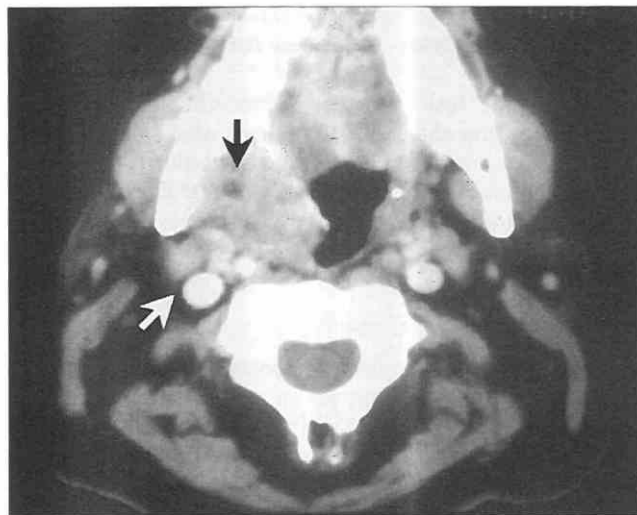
Prestyloid compartment parapharyngeal space infection from spread of tonsillitis. Axial contrast-enhanced CT scan at the level of the oropharynx demonstrates enlargement of the right faucial tonsil with obliteration of the prestyloid parapharyngeal fat on the right. One small area of decreased attenuation is noted within the inflammatory process, which may represent a small abscess cavity (*black arrow*). Fat planes surrounding the contents of the retrostyloid compartment of the parapharyngeal space remain intact (*white arrow*).
